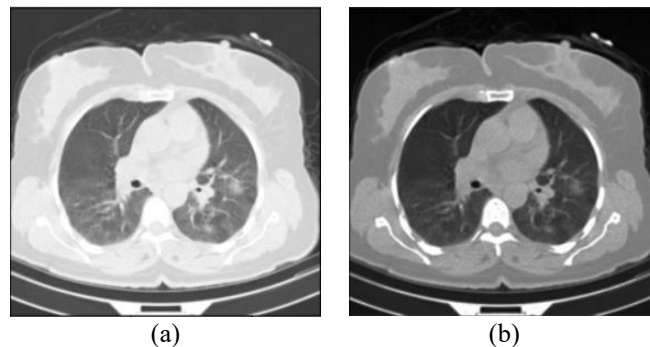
Fuzzy CT image enhancement (a) original CT image and (b) fuzzy colored enhanced image
